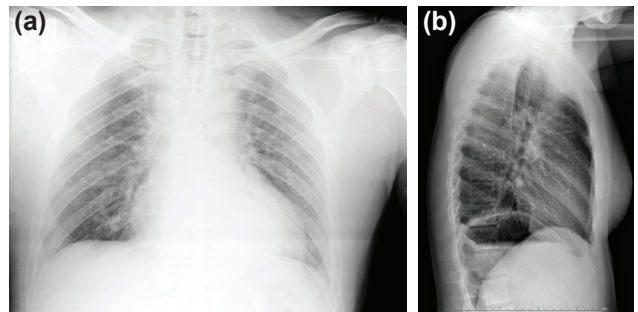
(a) A negative chest radiograph of a patient presenting with BDR (Case 12). (b) A diagnostic posteroanterior chest radiograph of a patient with a delayed DR that had occurred during gymnastic exercise. Immediate decompression with a nasogastric tube was required. An elevated left hemidiaphragm can be observed (Case 13).
